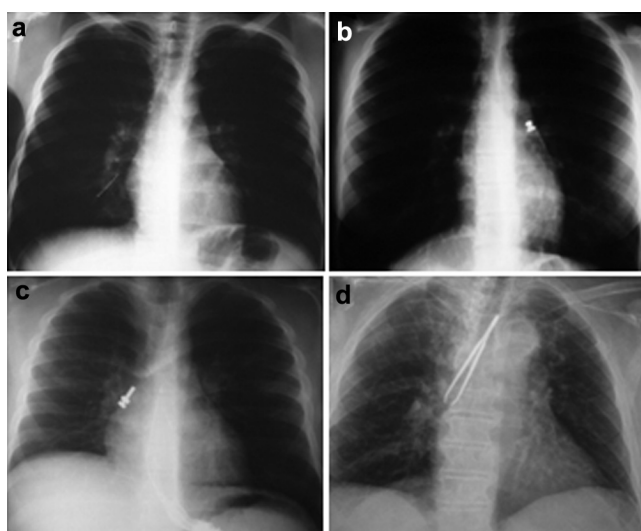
Posteroanterior chest radiographs showing different radiopaque foreign bodies. (a) Pin lodged in the medial basal segmental bronchus. (b) Rivet in the left main bronchus. (c) Screw lodged in the bronchus intermedius. (d) Hair clip lodged in the trachea.
